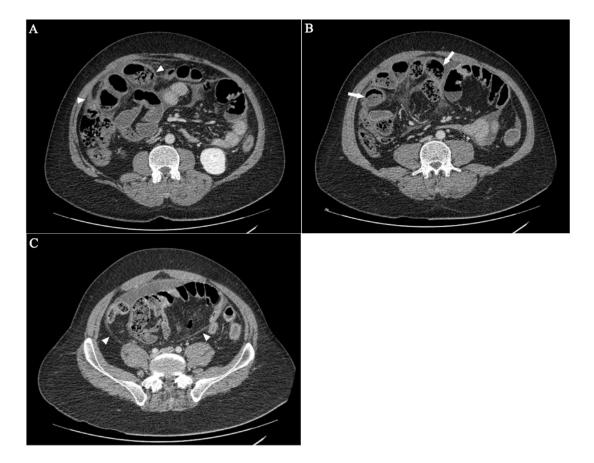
Axial post-contrast abdominopelvic CT images: White arrowheads (A and C) show smooth enhancing membrane encasing loops of small bowels which are assuming a cauliflower shape (white arrows in B). Loculated interloop ascites is seen in within the encasement in C.
